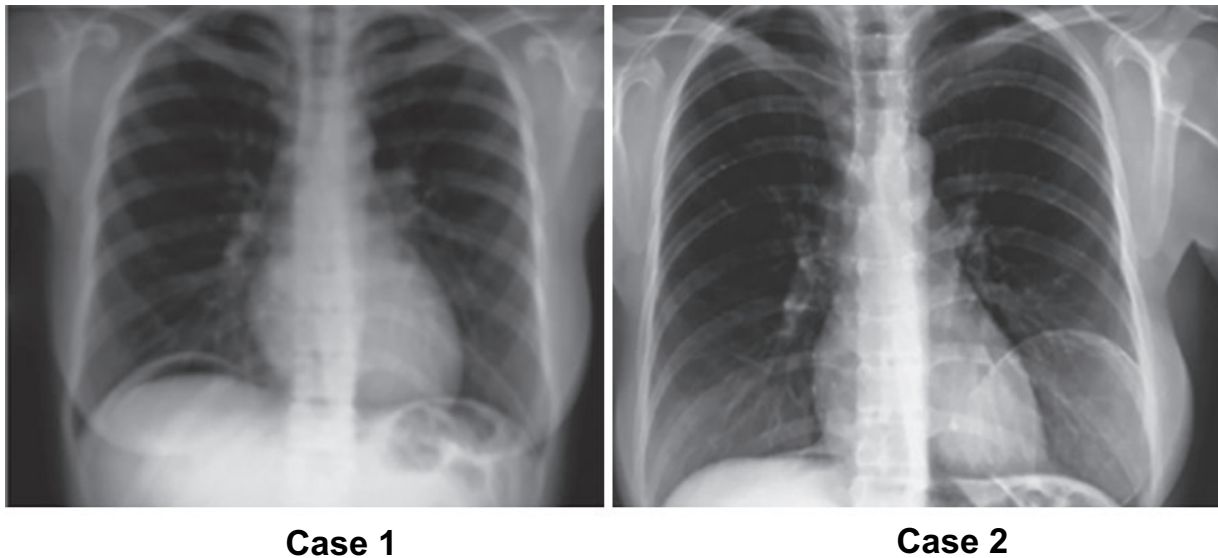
Examples of X-rays with residual pneumoperitoneum in which it can be appreciated the discrepancy between the Millitz's scale and the measurement of the residual volume.
